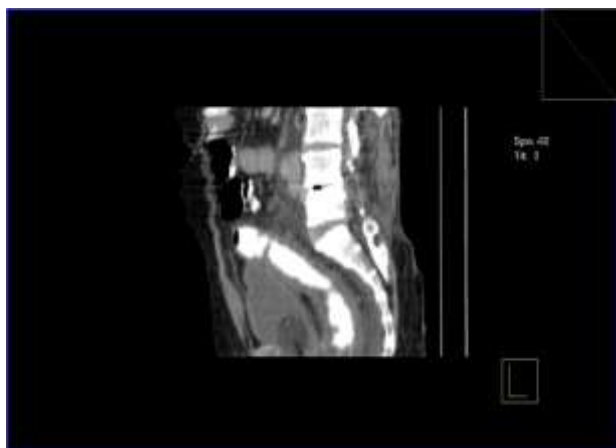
Reconstructed CT image revealed circumferential symmetric thickening of haustral folds with the appearance of thumb printing in case of ulcerative colitis (UC).
